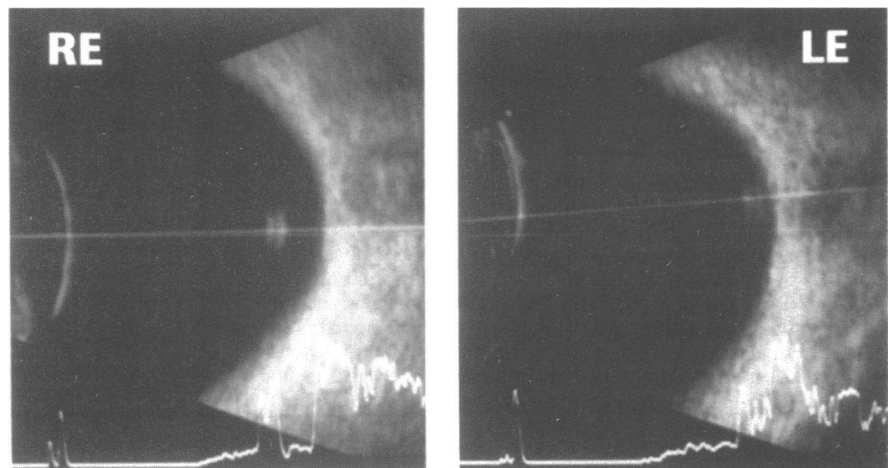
B-scan ultrasonography of the right eye (RE) and left eye (LE) showing the vitreous cysts.
